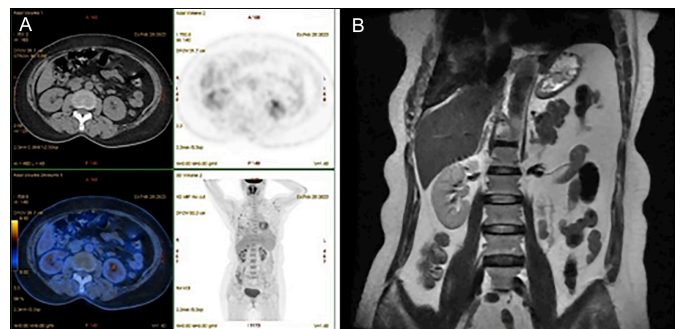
(A) Positron emission tomography-computed tomography whole-body fusion image showing nodular foci in the medial limb of the right adrenal gland. (B) MR scan of the renal region + adrenal glands + angiography enhancement scan suggesting no abnormalities in the adrenal glands bilaterally.
